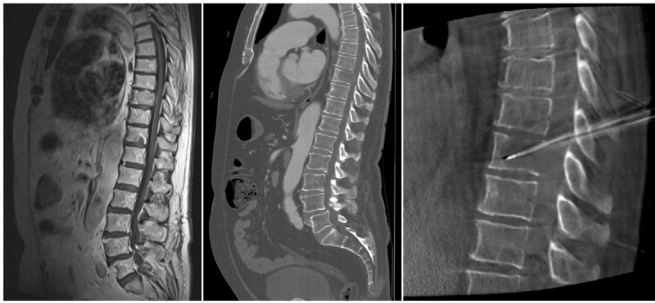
Image modalities that have been used for image-guided interventions of spinal metastases. Sagittal and axial T_1 -weighted, T_2 -weighted and T_1 -weighted contrast-enhanced (left) MR imaging sequences, as well as CT scans (middle) were acquired pre-interventionally. During interventions, flat-panel CT scans (right) support navigation and applicator placement. Artifacts due to low dose protocols, e.g. beam-hardening at the vertebral rim and from inserted metallic instruments aggravate precise metastasis localisation and puncture.
